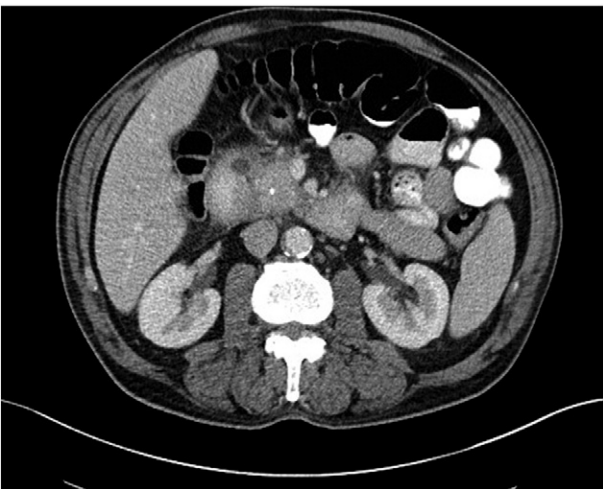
Axial contrast-enhanced CT (CECT) demonstrates another typical case of GP. This is an example of the “segmental form” with the round fibrotic mass centered in the pancreaticoduodenal groove but involving the head of the pancreas.
